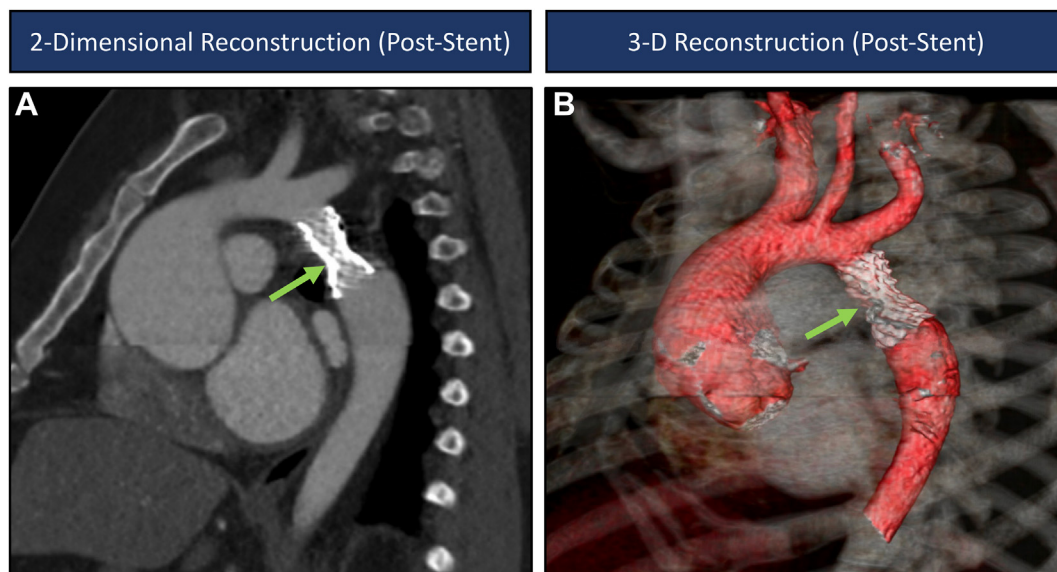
Cardiac computed tomography, oblique sagittal view, multiplanar (A) and volume-rendered reconstruction (B) of the aorta, demonstrates the coarctation following percutaneous repair with stenting (*arrows*) and improved patency. 3-D, Three-dimensional.
